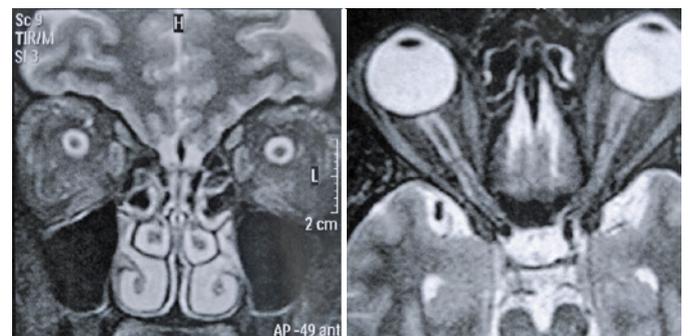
MRI of the brain and the orbits showing flattening of the globe, an enlarged optic nerve sheath, protrusion and enhancement of the optic nerve head, and vertical buckling of the optic nerve.
